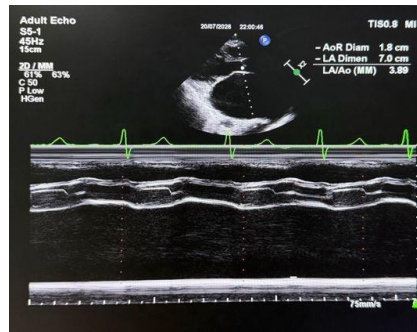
M-mode echocardiographic assessment demonstrating marked left atrial enlargement, with a left atrial diameter of 7.0 cm.
